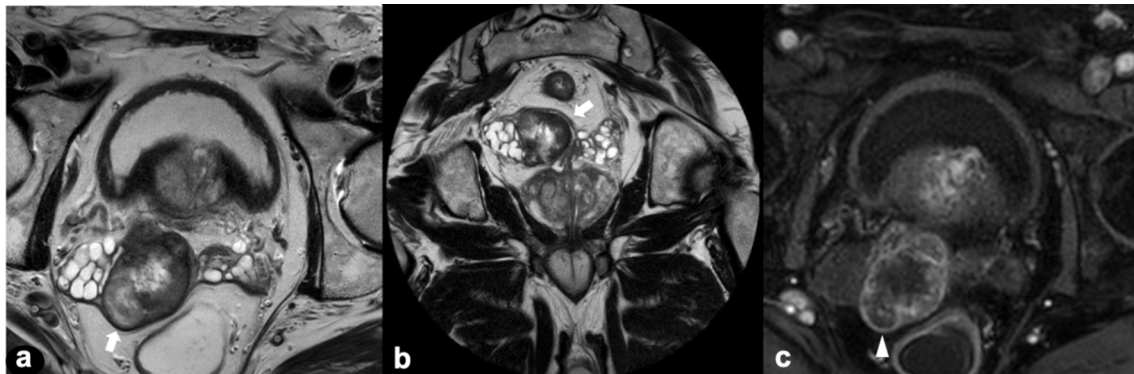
Axial (a) and coronal T2w (b) images show a heterogeneous encapsulated mass arising from the right seminal vesicle, with cystic and solid components (arrows) and with inhomogeneous enhancement on DCE image (arrowhead). Biopsy revealed leiomyoma. T2w T2-weighted, DCE dynamic contrast enhanced.
